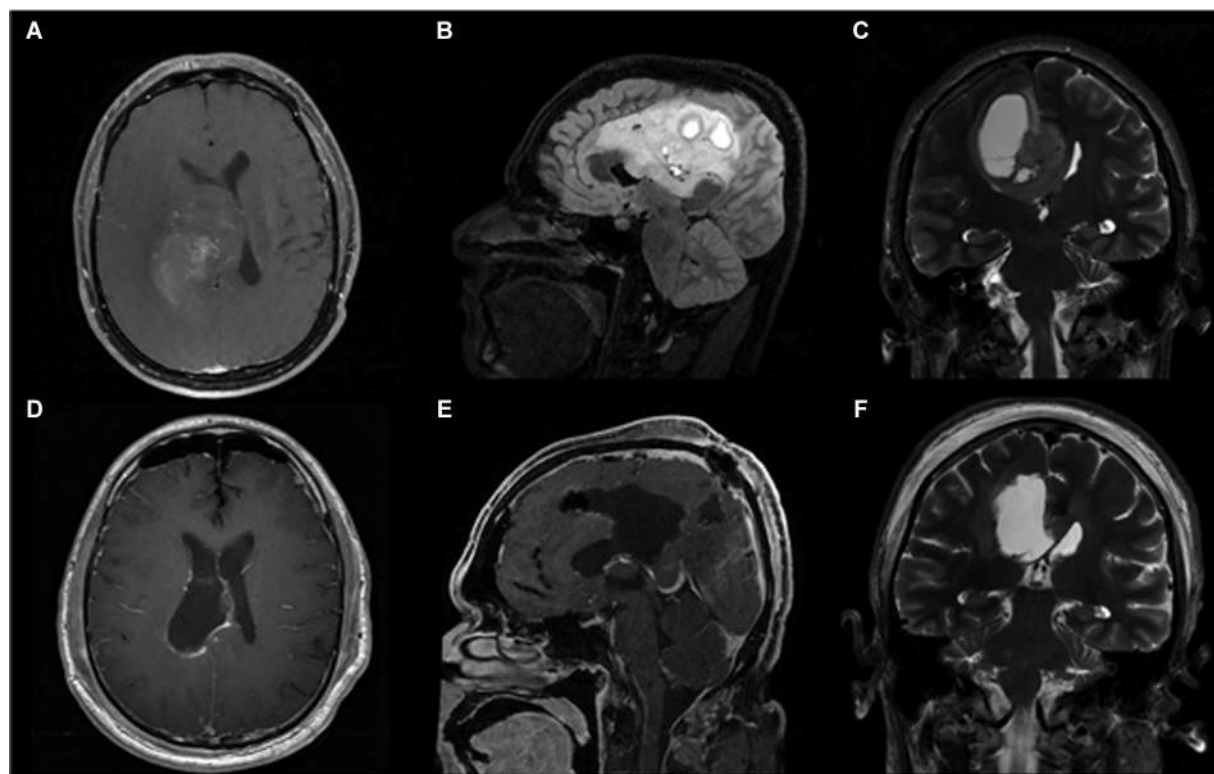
Axial gadolinium-enhanced T1-weighted (A), sagittal FLAIR (B) and coronal T2 weighted MRI (C) showing a right deep frontoparietal lesion with infiltration of the right cingulate gyrus and corpus callosum. Postoperative images: axial gadolinium-enhanced T1-weighted (D), sagittal gadolinium-enhanced T1-weighted (E) and coronal T2 weighted MRI (F) showing postoperative result with gross total resection without complications.
